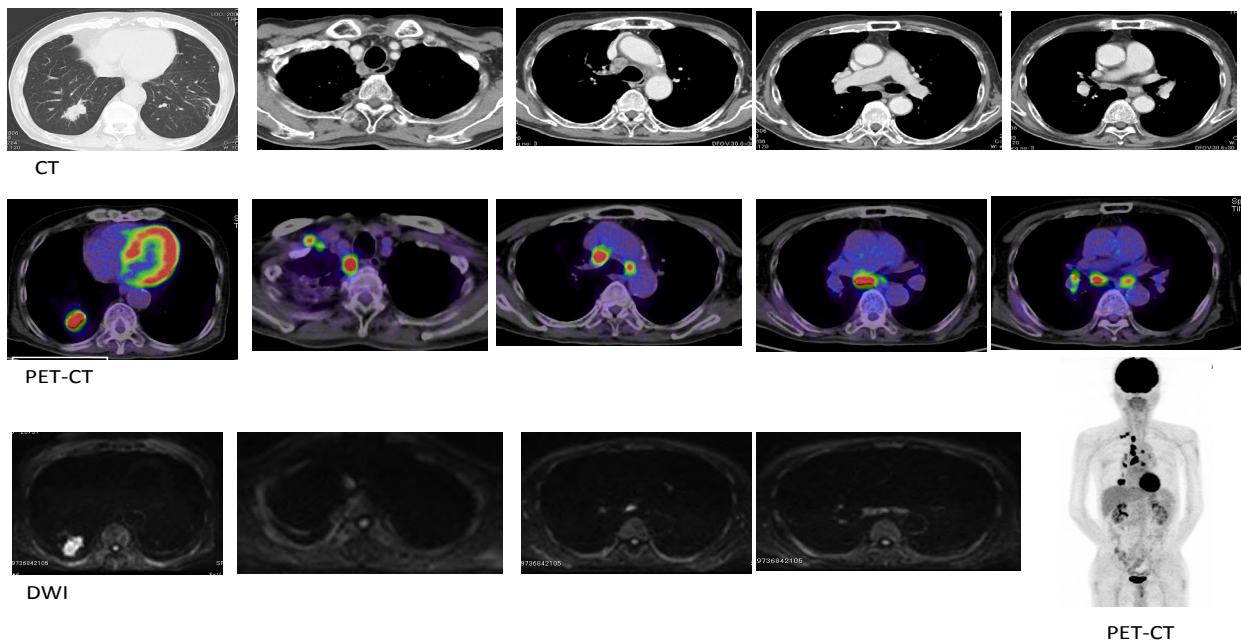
79 y.o. Male with Pulmonary Adenocarcinoma and Ipsilateral and Contralateral Pathological Nodal Involvement. Metastatic lymph nodes were diagnosed correctly by PET-CT and DWI
